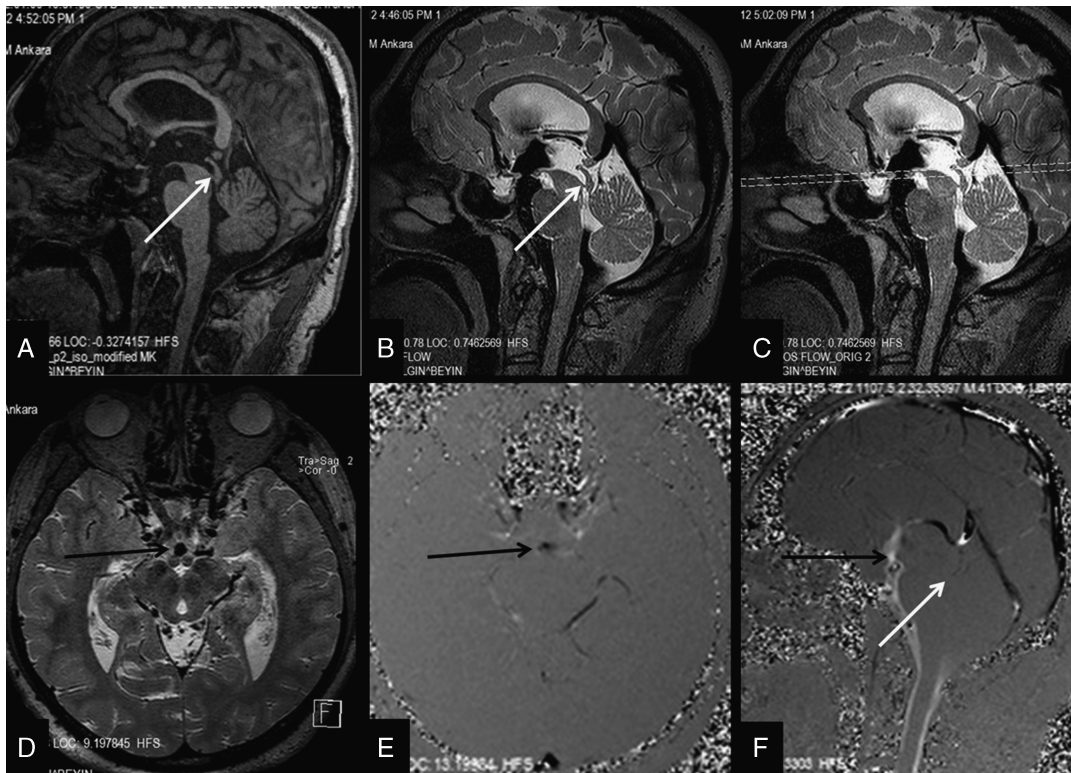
3D-MPRAGE (A), 3D-SPACE with variant FA mode (B–D), and PC-MRI (E, F) images of a 41-year-old male patient with aqueductal stenosis. Sagittal 3D-MPRAGE image demonstrates an aqueductal web (arrow, A). In sagittal 3D-SPACE image, hyperintense signal is seen at the level of aqueduct consistent with occlusion (arrow, B). In the same image, CSF flow with hypointense signal is detected from inferior wall of the third ventricle to prepontine cistern showing patent ETV stoma. On axial reformatted 3D-SPACE image (D), passing through stoma as shown in Figure 2C, morphology of ETV is better visualized. These findings in 3D-SPACE images were consistent with findings on axial (E) and sagittal (F) PC-MRI images. In these PC-MRI images, black arrows indicate patent stoma and white arrow shows aqueductal stenosis.
